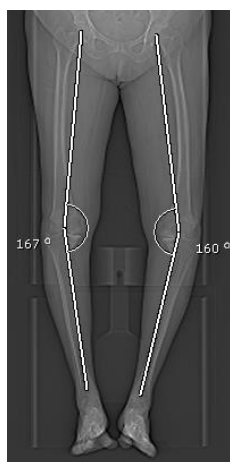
Preoperative CT Scanogram showing the femoral mechanical axis, tibial mechanical axis and measurement of MFTA in the same patient
